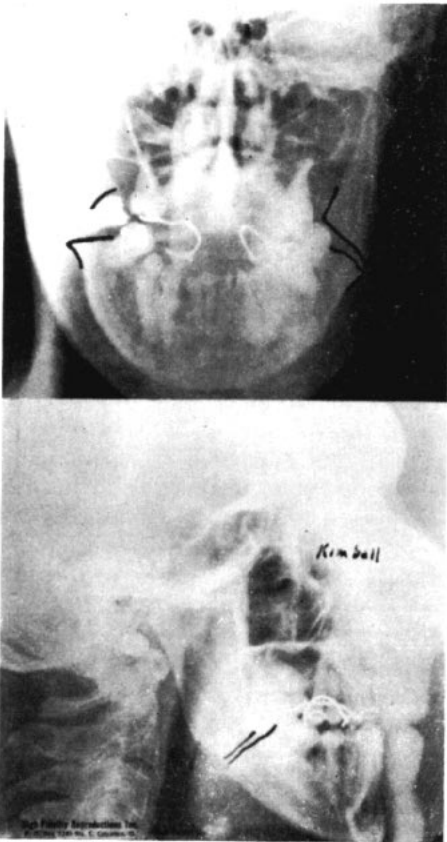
Above, photograph of x-ray taken before reduction; below, after reduction of fracture.
